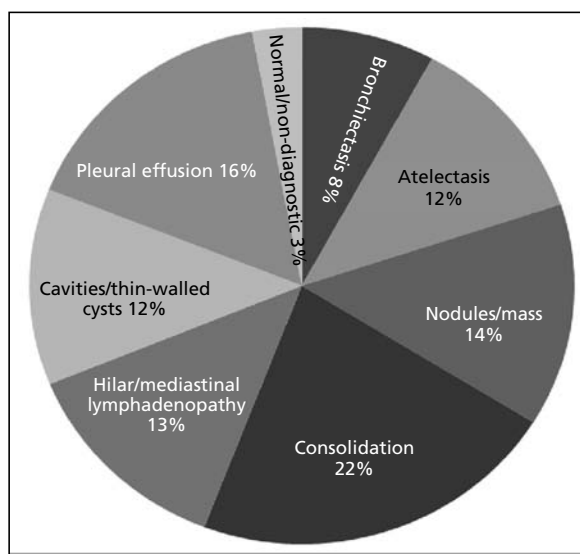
CT findings in patients with fever.
